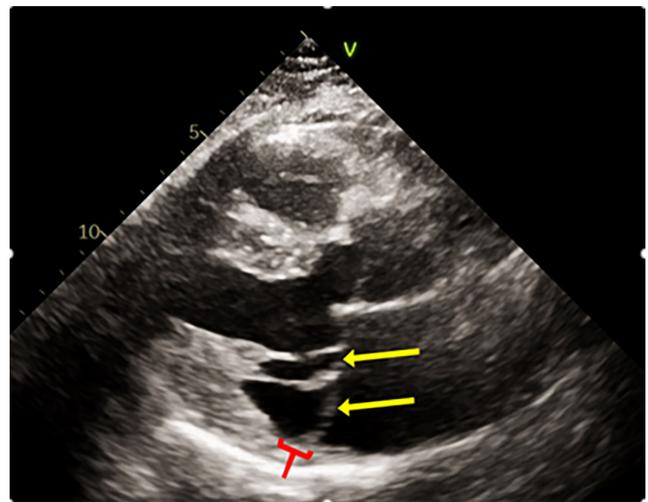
Transthoracic echocardiography demonstrating bileaflet mitral valve prolapse (yellow arrows) and mitral annular disjunction (red bracket) in Case 4.
